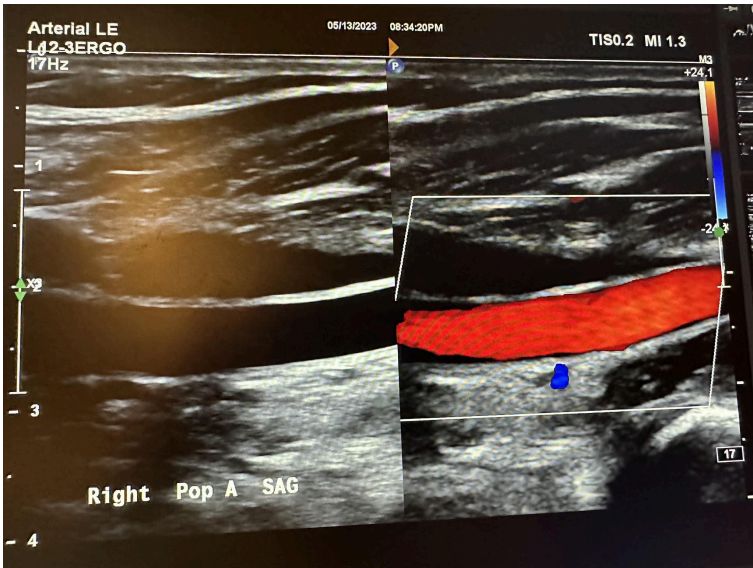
Side-by-side sagittal images of the right popliteal artery without color Doppler and with color Doppler.
